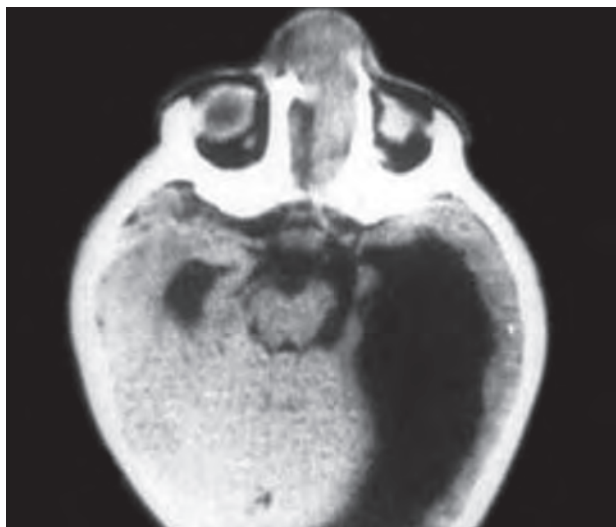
CT scan head of a child with nasoethmoid encephalocele which also reveals a porencephalic cyst
